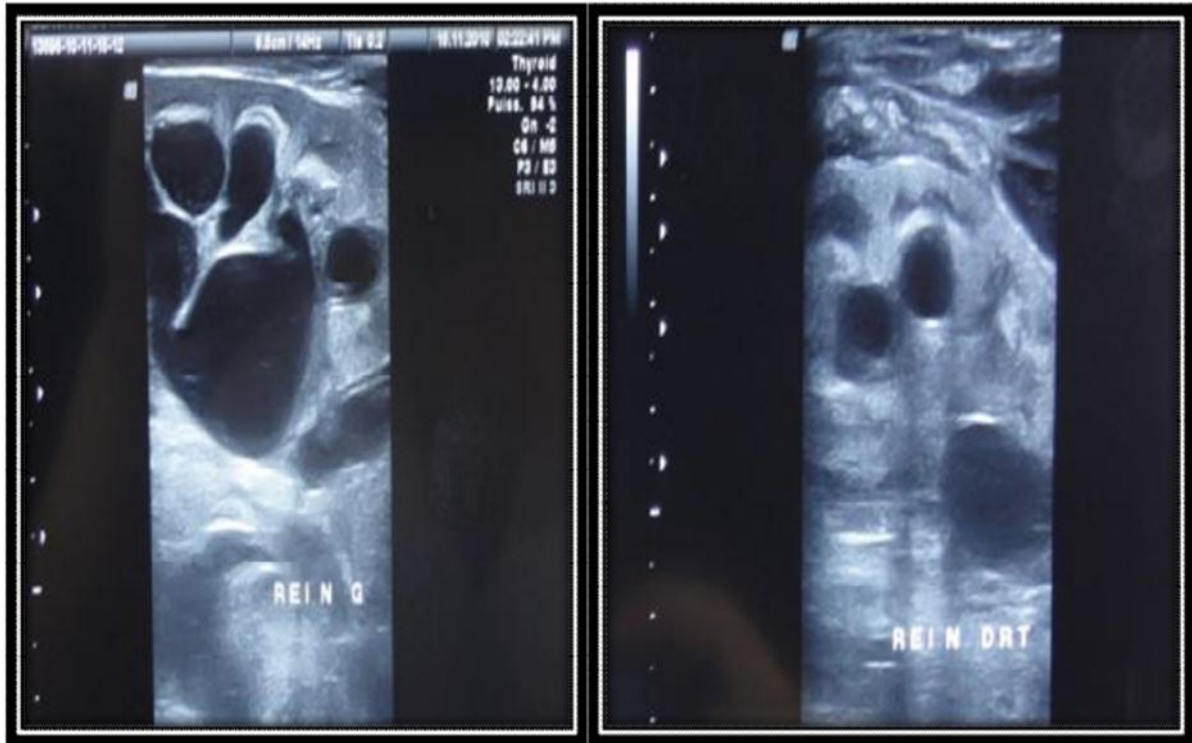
Bilateral HUN on renal ultrasound.
